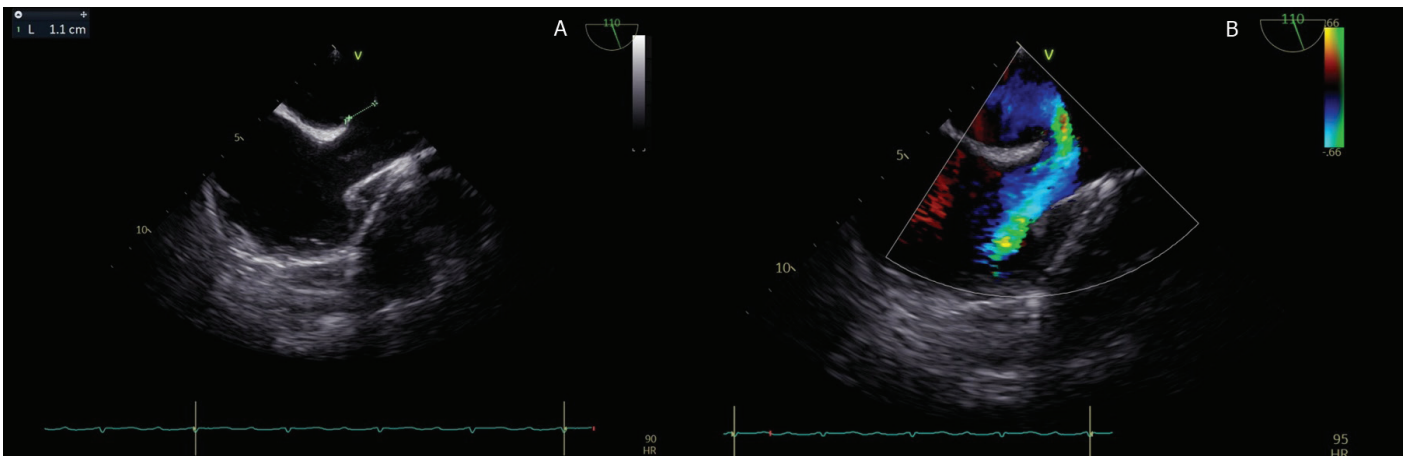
A. Bicaval view shows the defect size. B. Color Doppler shows the sinus venosus type ASD in the TEE image.
